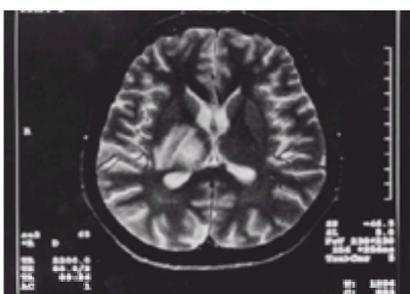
Involvement of the central nervous system (T_2 -weighted MRI showing a hyperintense lesion in the right thalamus, capsula interna, and nucleus lentiformis in a 28-year-old male patient).
